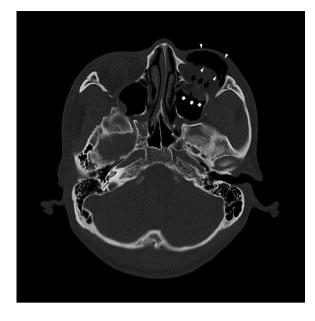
Computed tomography (CT) shows subcutaneous emphysema around the left orbit. Axial CT shows the left inferior orbital wall fracture (white arrows), herniation of orbital fat through the fracture (black arrows), and orbital emphysema (arrowheads)
